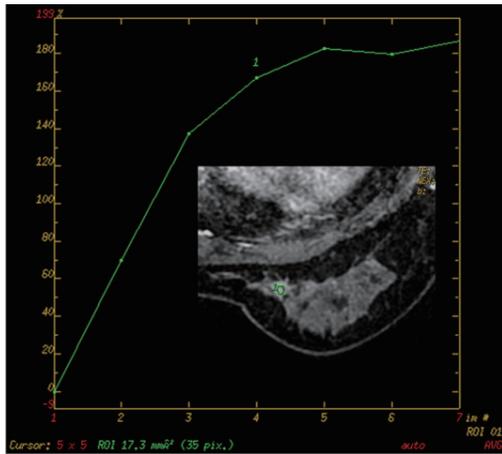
Persistent (type 1) curve: breast adenosis A suspected lesion is found in right breast after surgery for cancer in left breast. BI-RADS-MRI category 3 is considered. Pathology, Breast adenosis, with papillary hyperplasia in the epithelia of individual ducts
